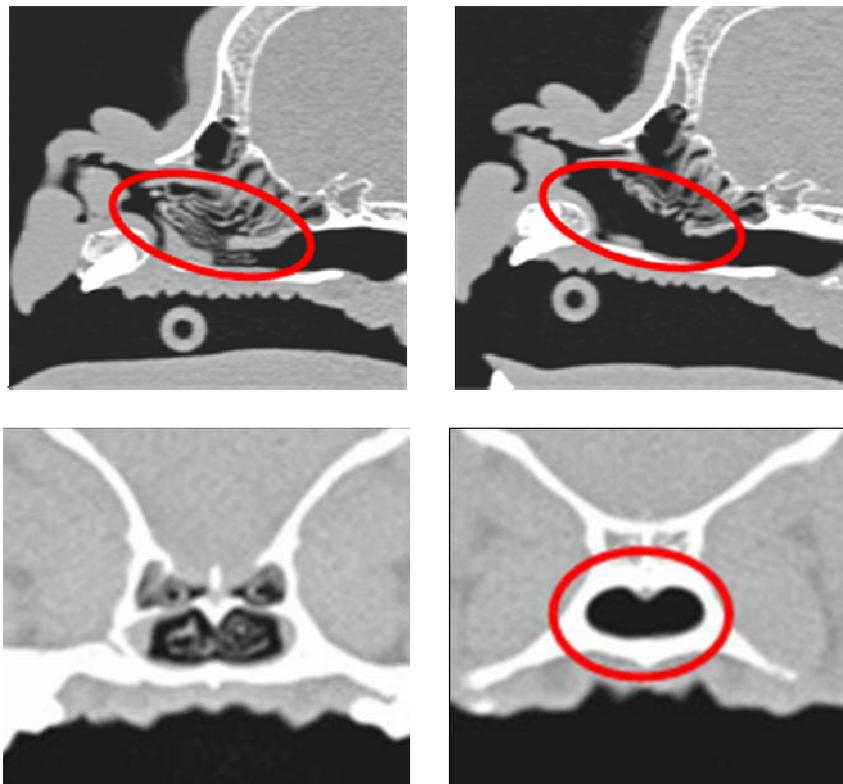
Sagittal and axial CT scans before and after LATE-surgery.
